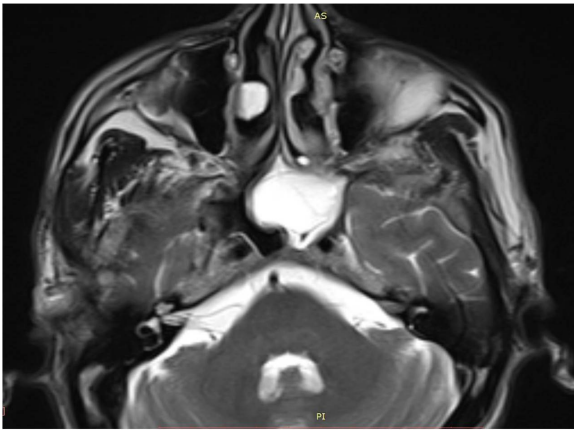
Preoperative axial magnetic resonance imaging showing a cystic mass in the left sphenoid sinus.
